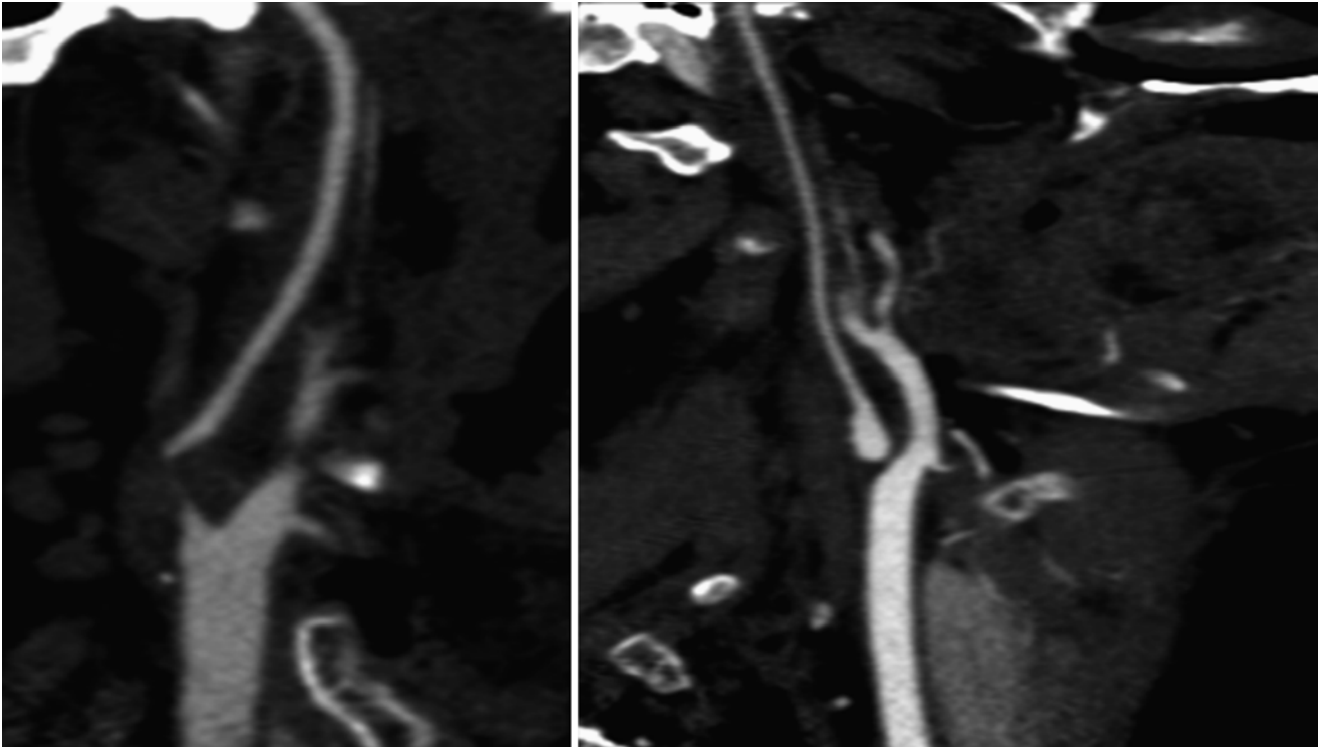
CTA is the most appropriate noninvasive method, short of DSA, for differentiating pseudo-occlusion from true complete occlusion
